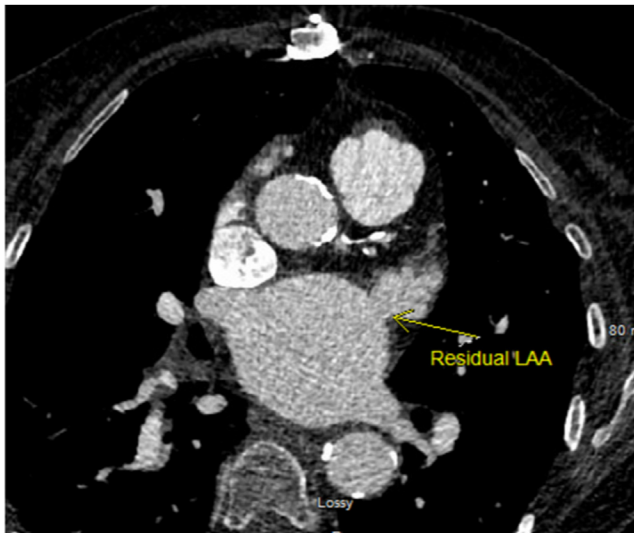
Coronary computed tomography angiography demonstrated residual communication between the left atrium and the left atrial appendage (LAA).
